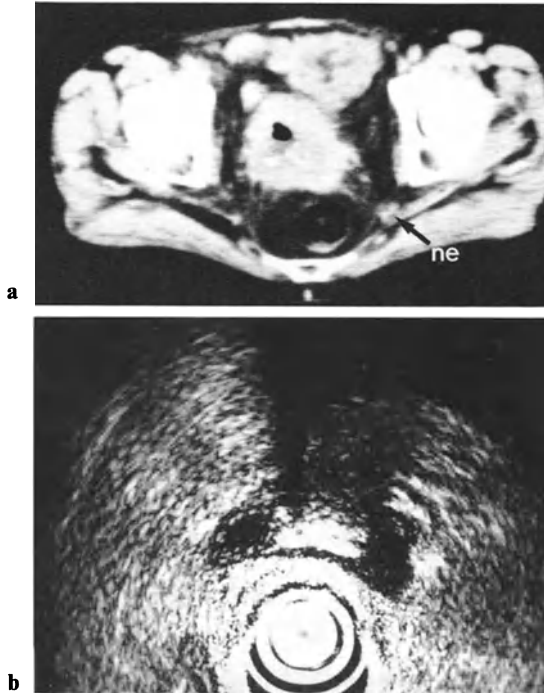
a, b. CT and RS: carcinoma of cervix stage IIIb. a CT shows a bulky tumor mass with central necrosis and irregular contrast enhancement with nodular tumor extension (*ne*) to the left pelvic wall. b RS demonstrates the central portion of the tumor with a necrotic area, but the nodular spread to the left pelvic wall is missed
